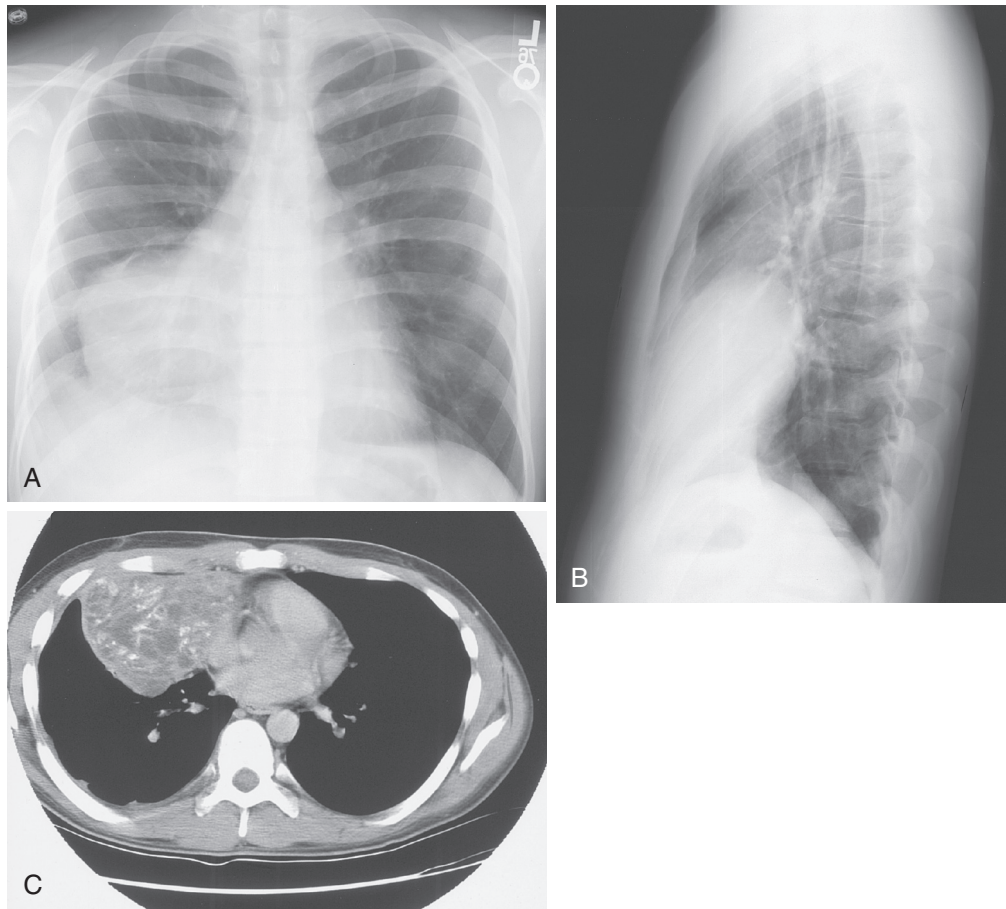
■ (A) Posteroanterior and (B) lateral chest radiographs from a 21-year-old man showing a large mediastinal mass adjacent to the right cardiac border. This appearance is characteristic of a mediastinal teratoma. The CT scan (C) shows a complex cystic mass with solid components, including fat and calcification consistent with a diagnosis of teratoma. In the absence of metastatic disease, the final differentiation between teratoma and teratocarcinoma can be made only by pathologic review. (A and B, Courtesy Wallace T. Miller, Jr., Hospital of the University of Pennsylvania, Philadelphia.)
